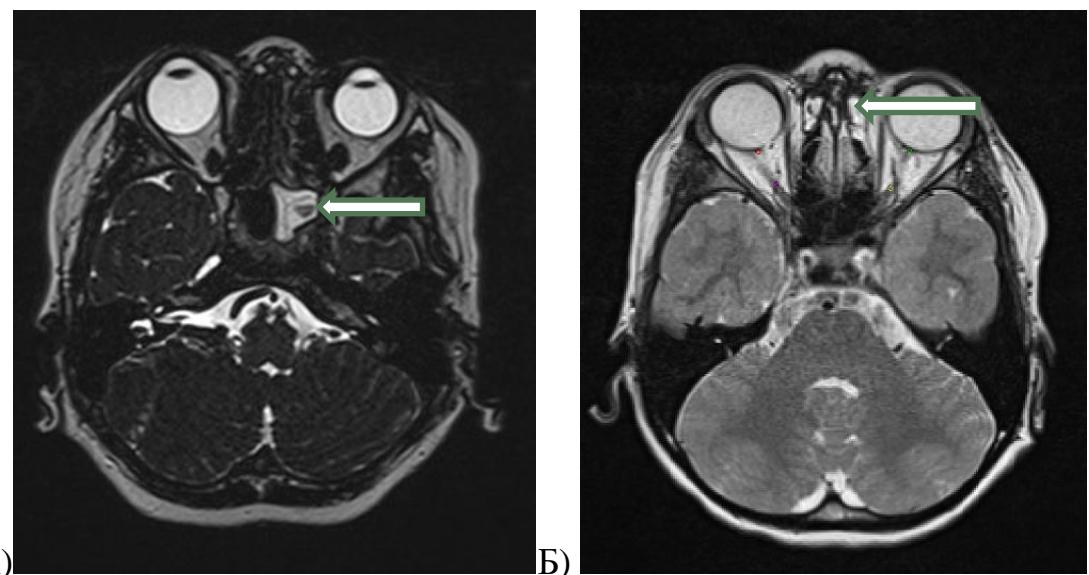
MRI of the brain A) presence of mucosal hyperplasia in the sphenoid sinus B) presence of mucosal hyperplasia in the ethmoid sinuses.
